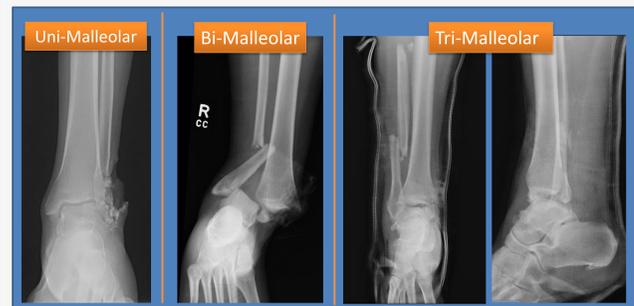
Pre-operative radiographs demonstrating number of malleoli
